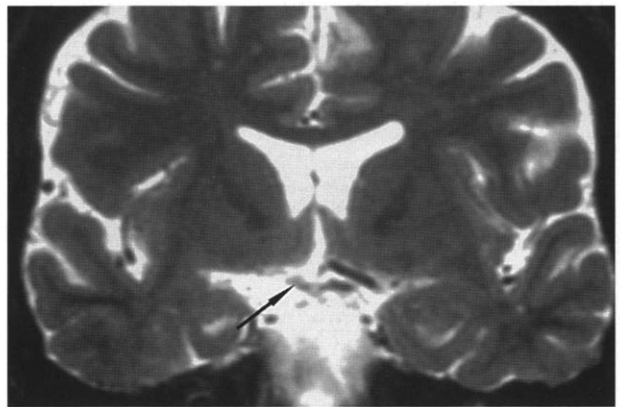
Coronal T<sub>2</sub>-weighted MRI image of brain through optic tract obtained 5 months after injury, showing atrophic optic tract (arrow).
